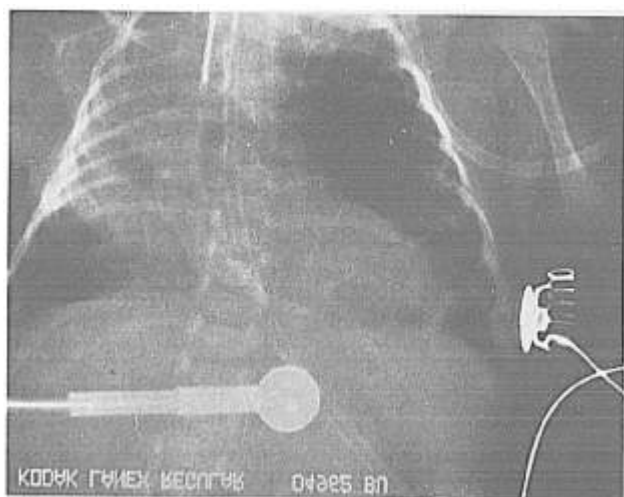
Patient's preoperative chest radiograph demonstrating severe bilateral pulmonary interstitial emphysema. The hyperaerated left lung extends across the midline into the right chest. An endotracheal tube is in place, as is an orogastric tube.
